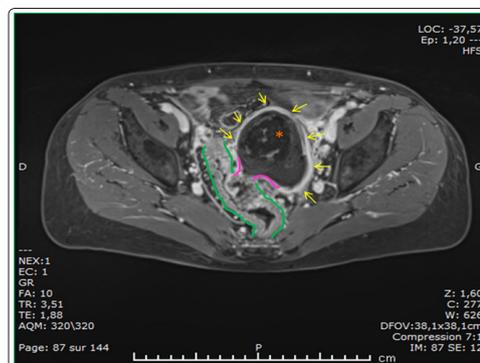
Axial section of a pelvic MRI in T1 sequence with gadolinium injection. Yellow arrows show the thickened walls of the left ovarian dermoid cyst containing fat and sebum (orange asterisk); green lines show the infiltrated and thickened sigmoid wall and the pink lines the fistula between these two organs.
